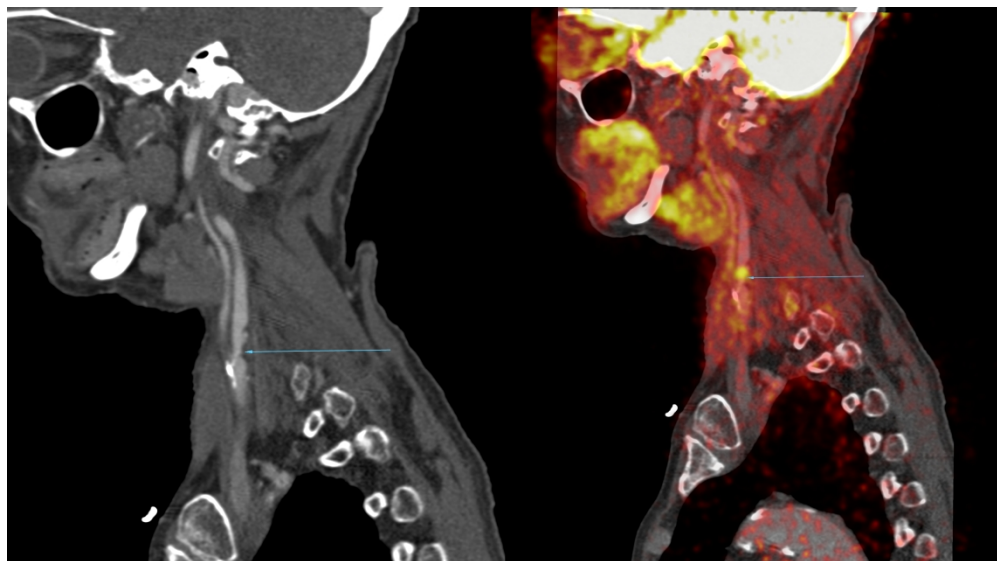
(a) and 4(b): (a) CTA shows a moderate (~50%) stenosis of the left proximal internal carotid artery (blue arrow) in a recently symptomatic stroke patient presenting with right sided weakness and dysphasia. (b) Co-registered 18F-FDG PET-CTA of same patient shows increased focal FDG-uptake in the region of the carotid plaque.
